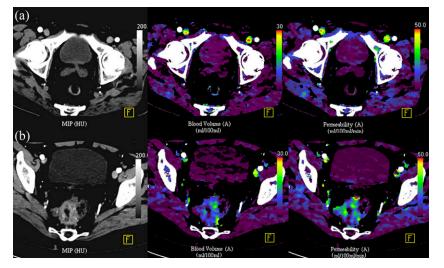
Perfusion CT characteristics of the normal rectum (a) compared with a cancer (b).
